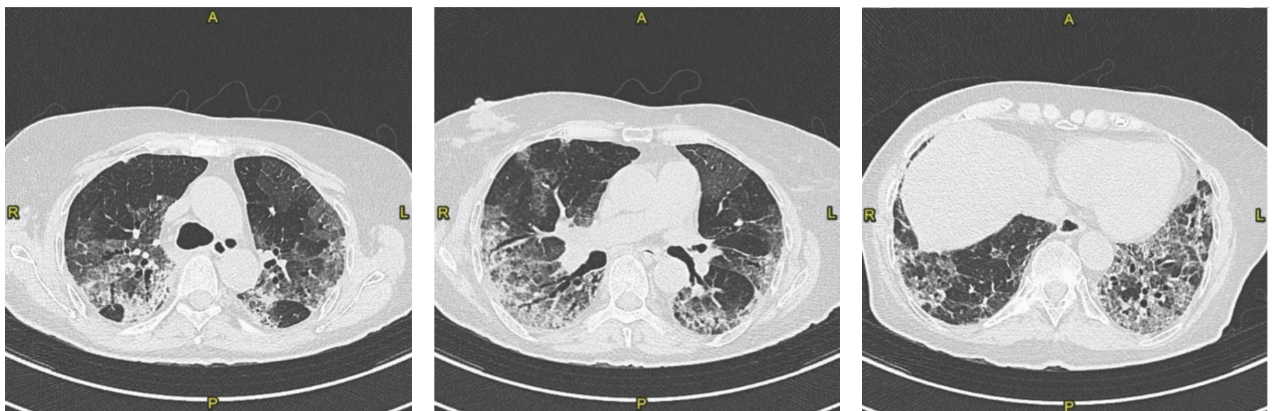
CT scan after 2 weeks from the previous one (April 2020): Fibrotic evolution of interstitial pneumonia. Decrease of the ground glass opacities with peribronchial consolidating areas of organized appearance with contextual traction bronchiectasis. Visual score of 60%.
